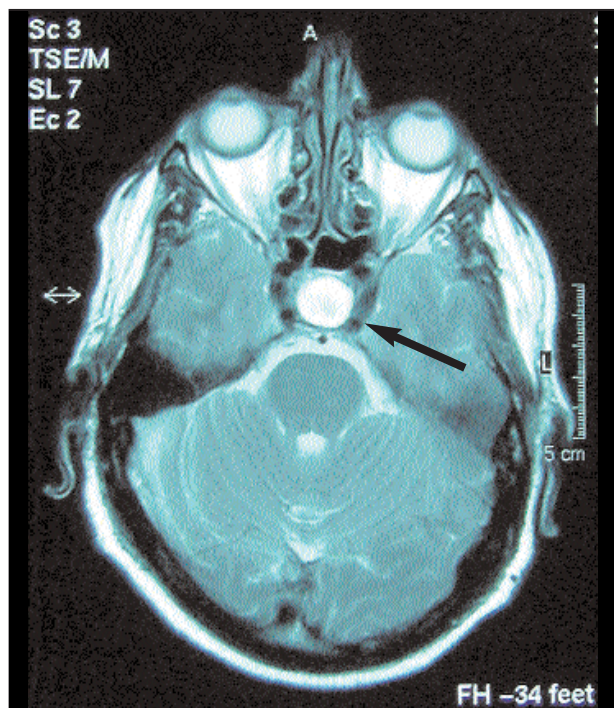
MRI showing a pituitary mass in a 70 year old male who presented with a sudden headache vomiting and dizziness. The CT was reported as normal, but in retrospect showed an enlarged pituitary fossa. He had profound hyopituitarism
